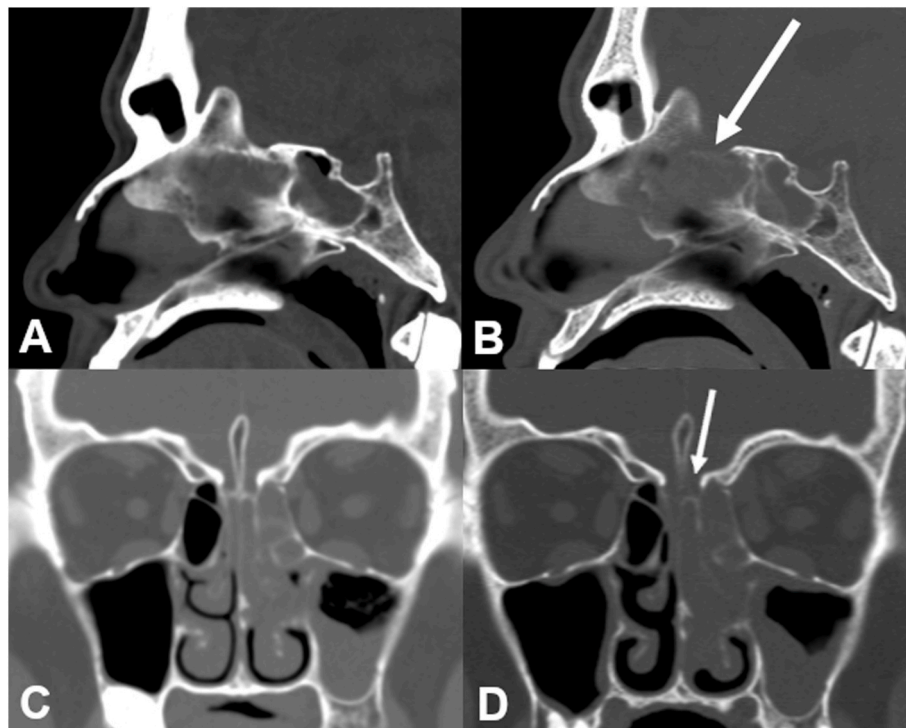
CT imaging prior to diagnosis (A,C) and at time of diagnosis (B,D) showing unilateral soft tissue thickening within the left nasal cavity with new bone erosion at the anterior skull base on the follow-up imaging (white arrows).
